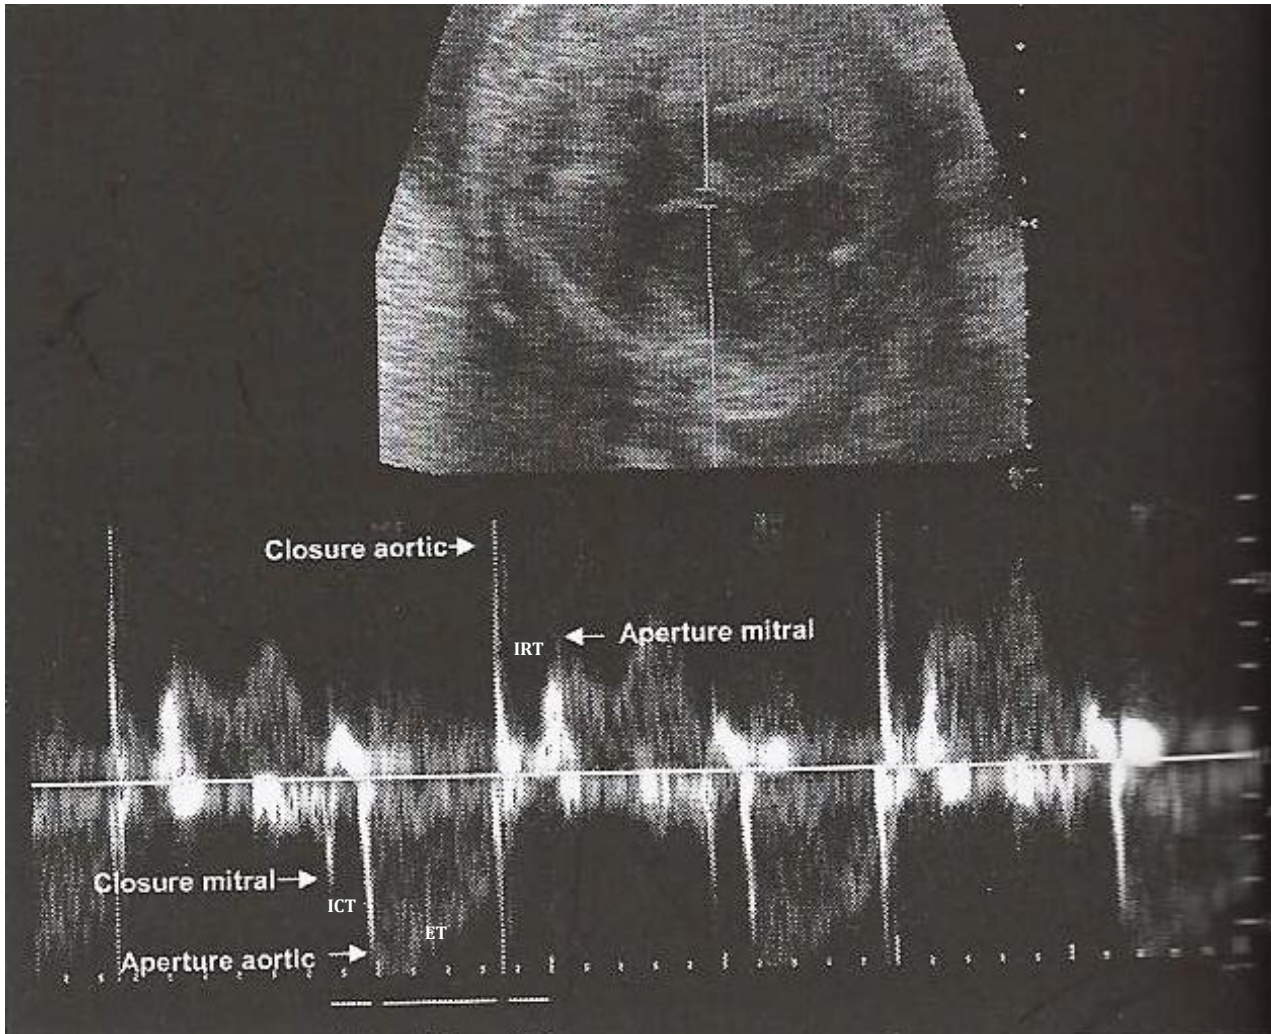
Doppler Echocardiography of Fetal Cardiac Cycle
